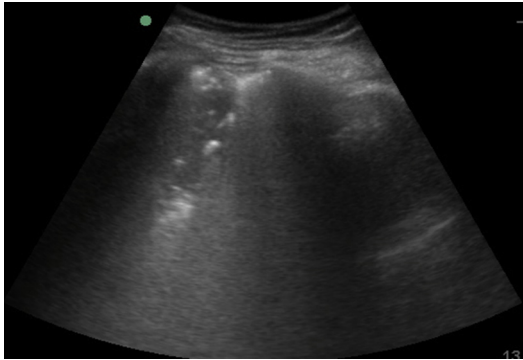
Ultrasound image showing air bronchograms suggestive of pneumonia. (Courtesy of Highland Emergency Medicine, Oakland, CA.)
